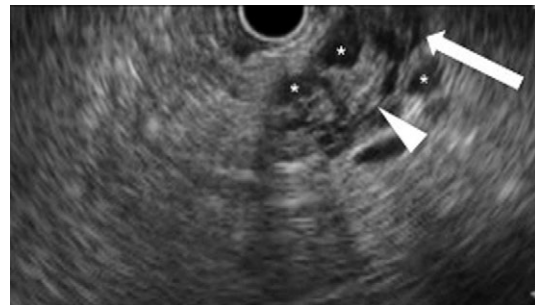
Endoscopic ultrasonography showing an iso-hypoechoic heterogeneous nodule, protruding within the main pancreatic duct (MPD; arrow head), a dilated upstream MPD (arrow), and multiple small cysts around the nodule (asterisk).
